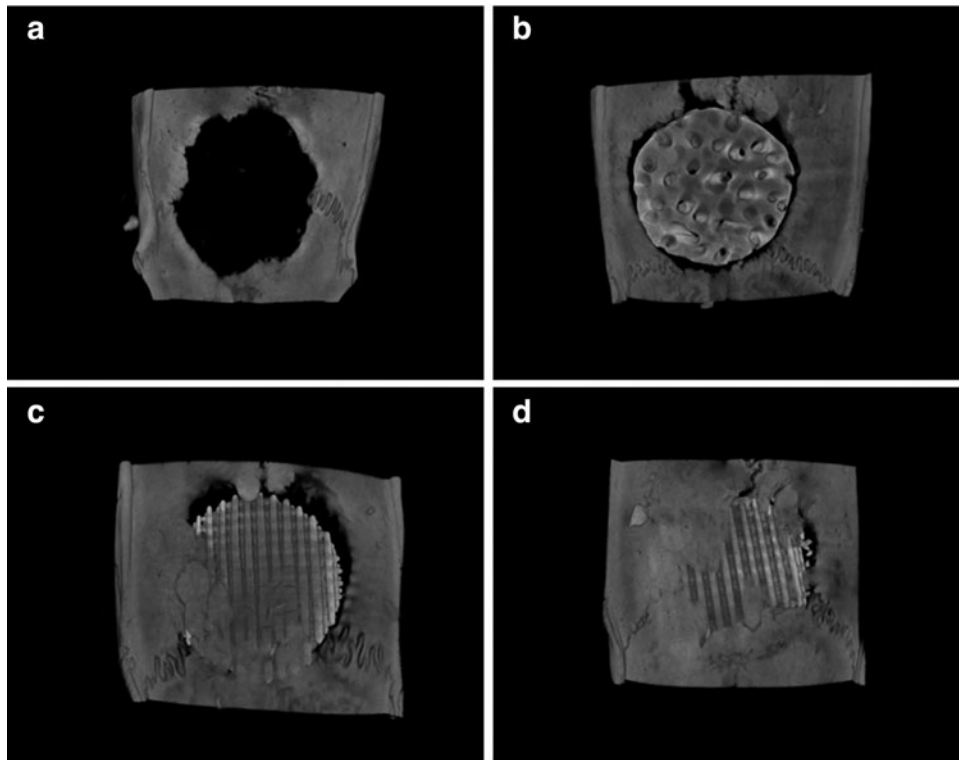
Micro-computed tomography (CT) images showing new bone formation at the 16th week after implantation: (a) blank, (b) BABI-HAP-PD, (c) hydroxyapatite (HA), and (d) HA/tricalcium phosphate (TCP).
